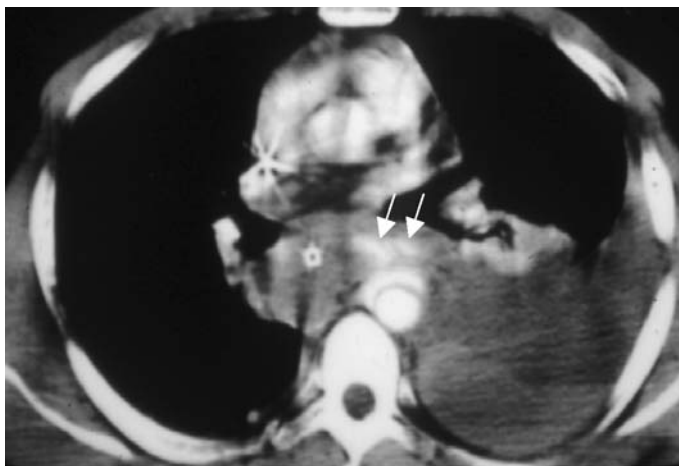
CT scan of a traumatic aortic injury with signs of impending rupture. Note contrast media extravasation outside the adventitial wall (arrows). A wide pleural hemorrhagic effusion is also visible.
